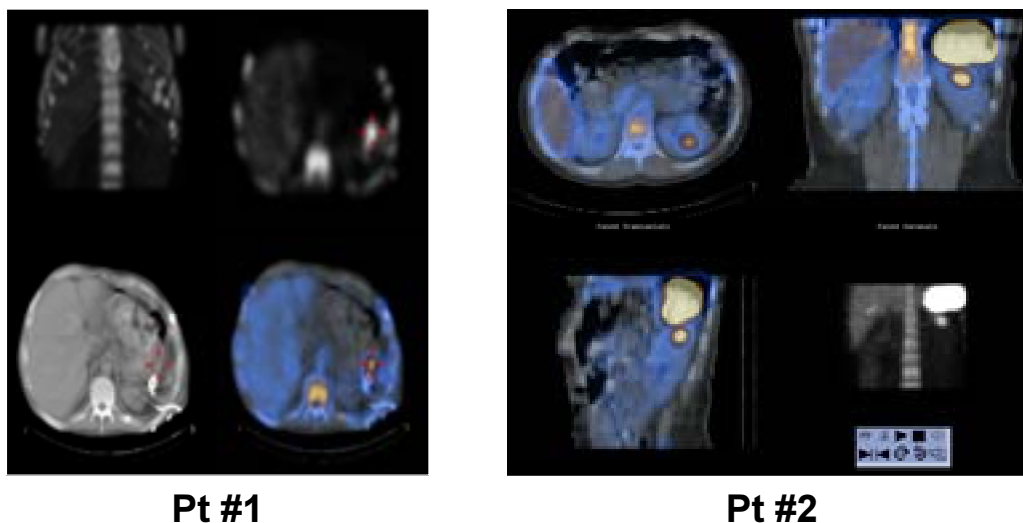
Patients with infectious foci in the abdominal area. Pt # 1 (left panel) developed persistent fever resistant to antibiotic treatment shortly after combined pancreatectomy and splenectomy, performed because of a pancreatic adenocarcinoma of the tail infiltrating the splenic hilus. SPECT/CT performed as part of autologous ^{99m}Tc -HMPAO-leukocyte scintigraphy reveals a sub-diaphragmatic abscess at the tip of the draining catheter that had been placed during surgery. Pt #2 (right panel) had instead fever of unknown origin. During autologous ^{99m}Tc -HMPAO-leukocyte scintigraphy, it is only SPECT/CT that reveals location of an abscess at the upper pole of the left kidney, which on planar scan could only be generically located below the lower pole of the spleen.
